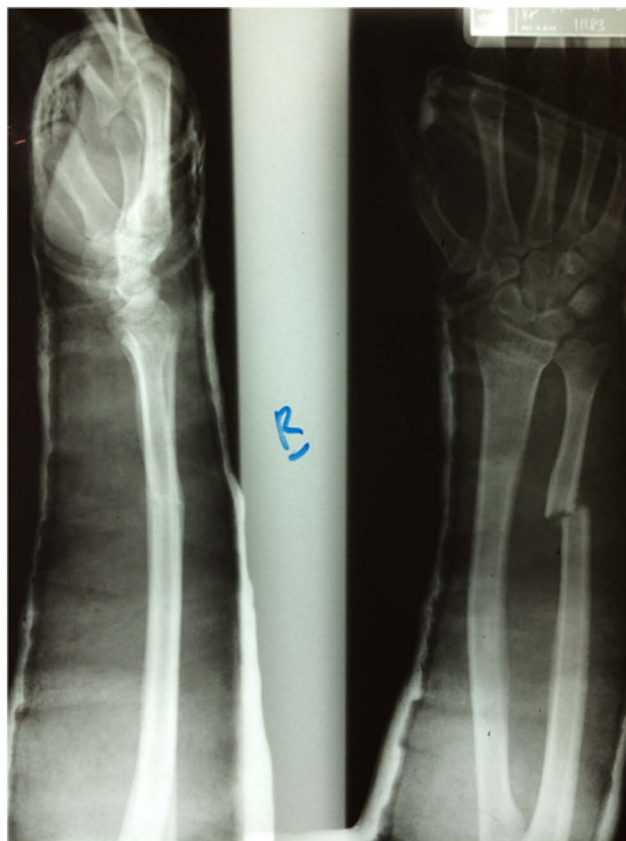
Plain radiograph revealed an isolated displaced fracture at the junction of distal and middle third shaft of left ulna.
